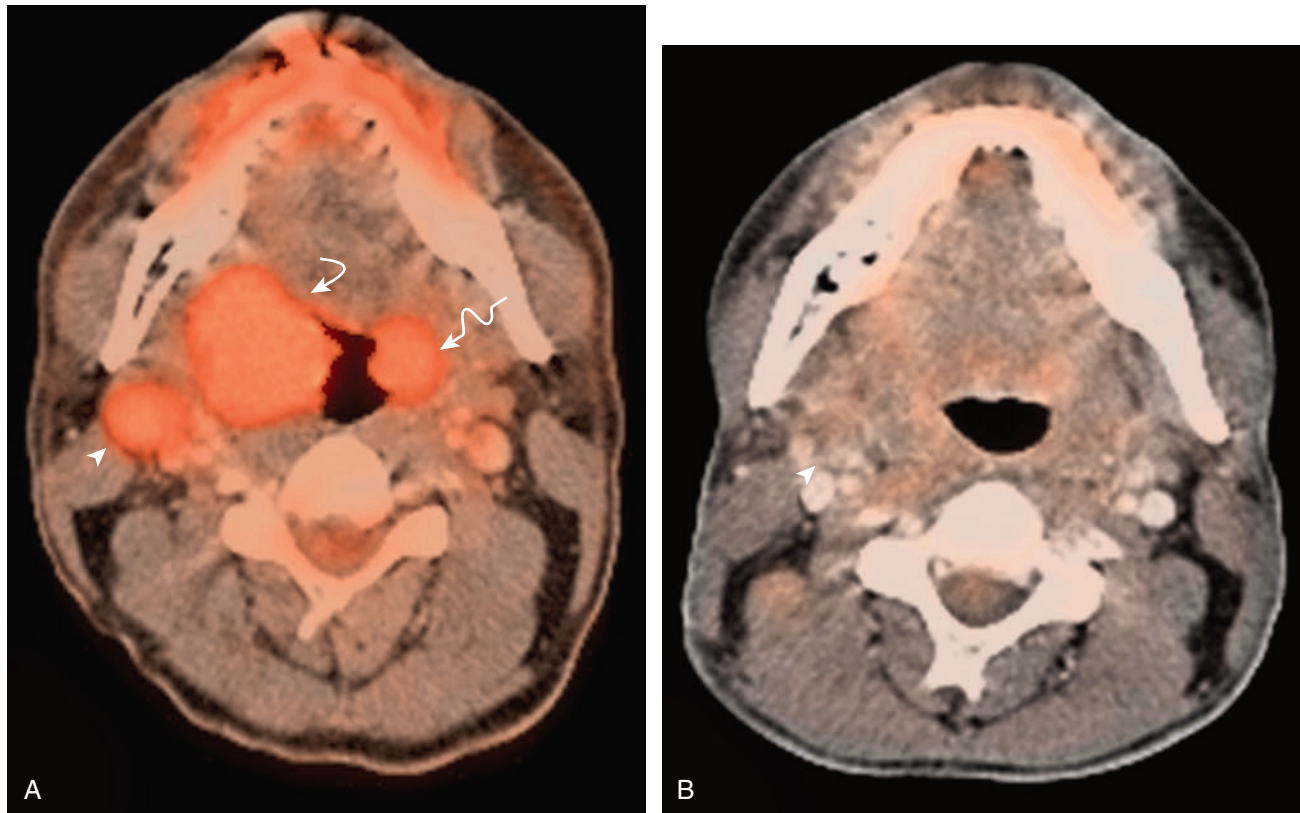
PET/CT scan in tonsillar carcinoma.
